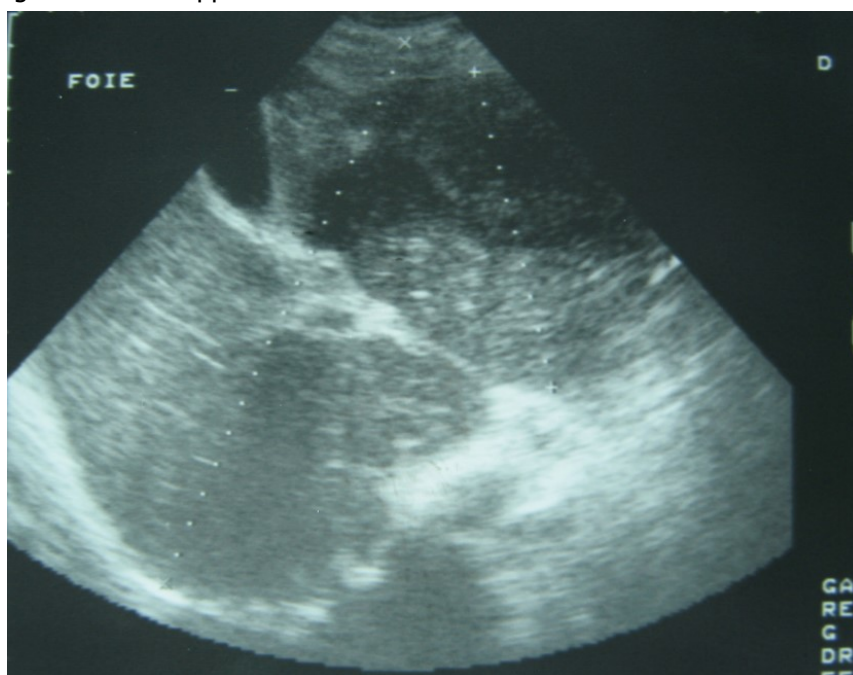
Ultrasonography showing a 10 cm hypoechoic lesion
